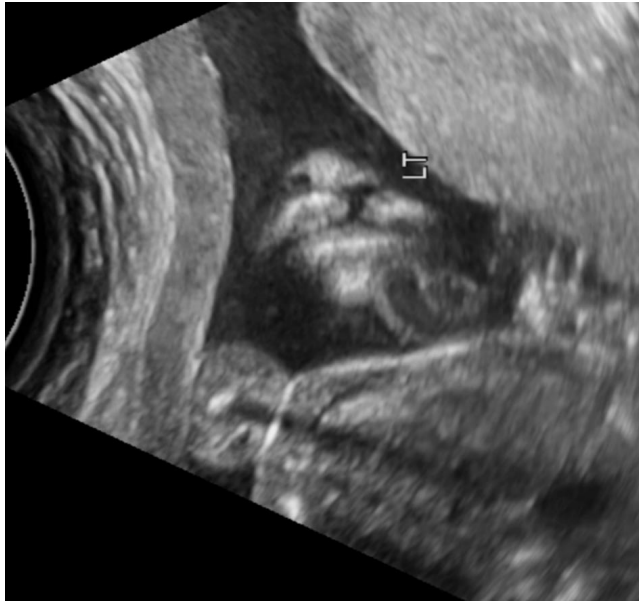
Facial Clefting. Ultrasound (Coronal plane).
